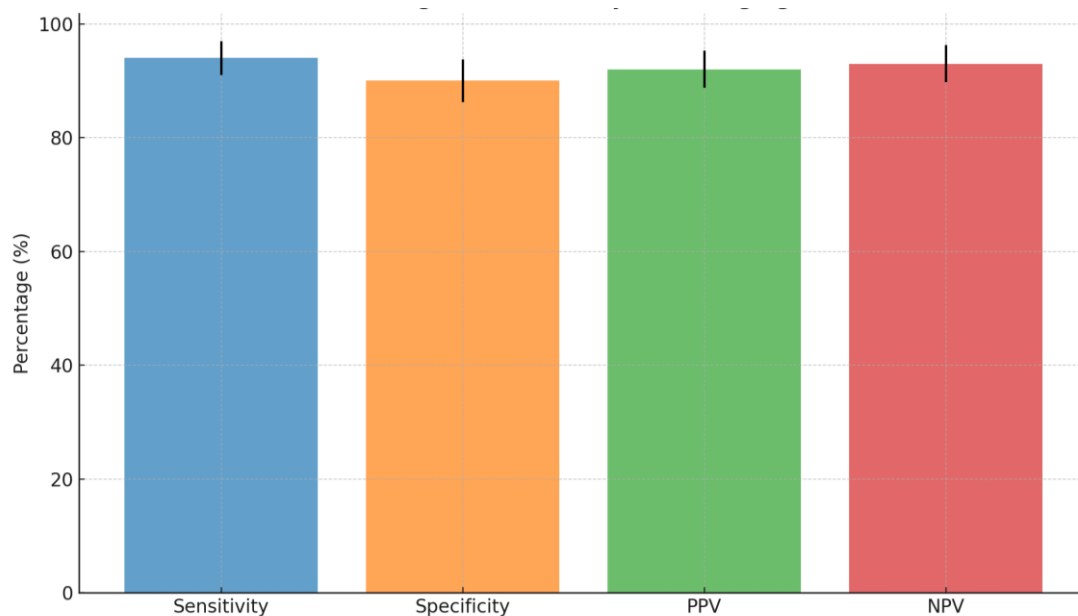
Diagnostic Accuracy -CT Imaging
